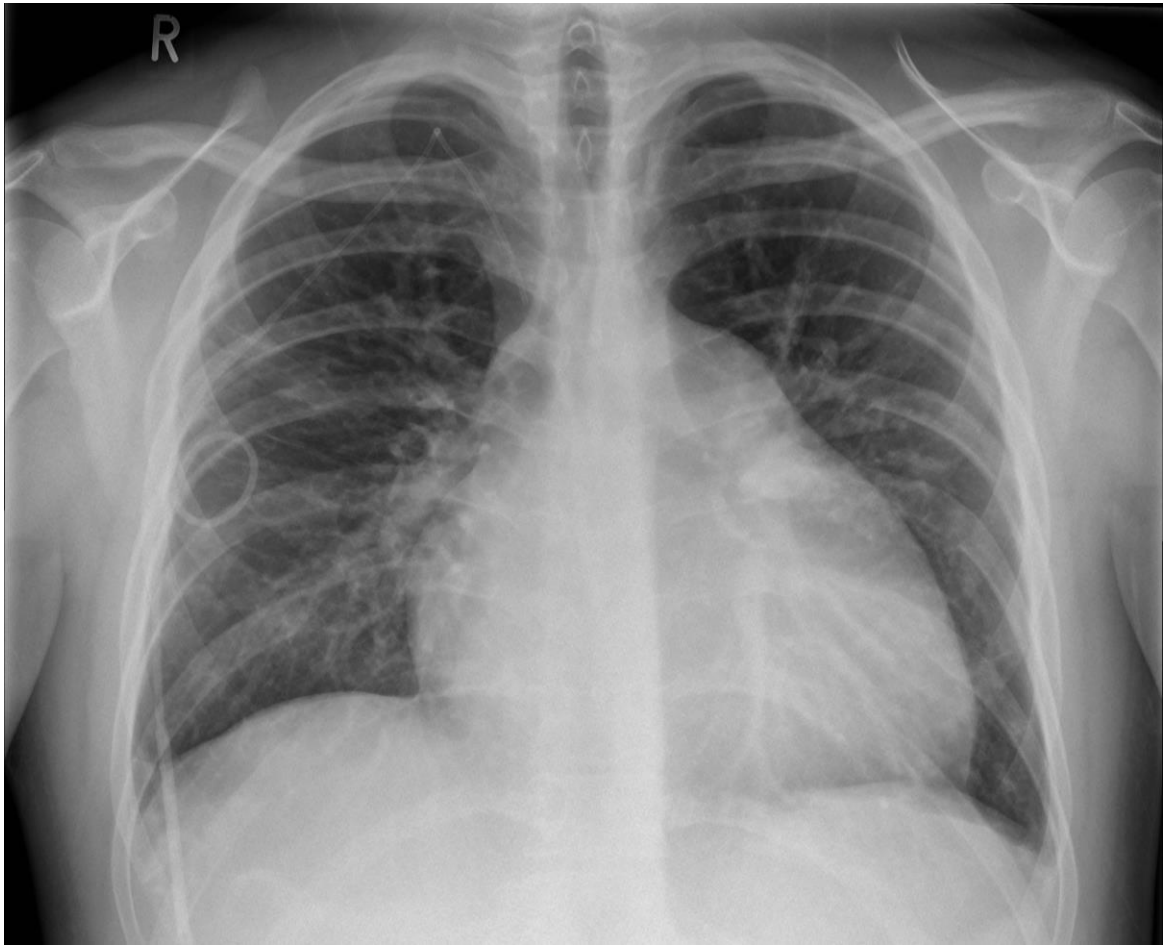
The typical chest radiographic features of pulmonary hypertension in a patient with IPAH. *The chest radiograph shows cardiomegaly with dilatation of the main pulmonary artery. There is a tunnelled central line for intravenous delivery of iloprost.*
